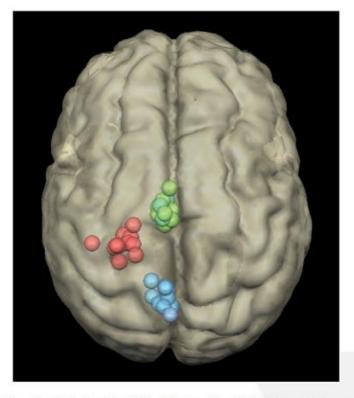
Localization of the cTBS sites in the 12 participants for the SMA (green), M1 (red), and control (blue) conditions. These coordinates were obtained by projecting the stimulation sites onto the individual brain MRI of each participant, which was then normalized into the Talairach space.
